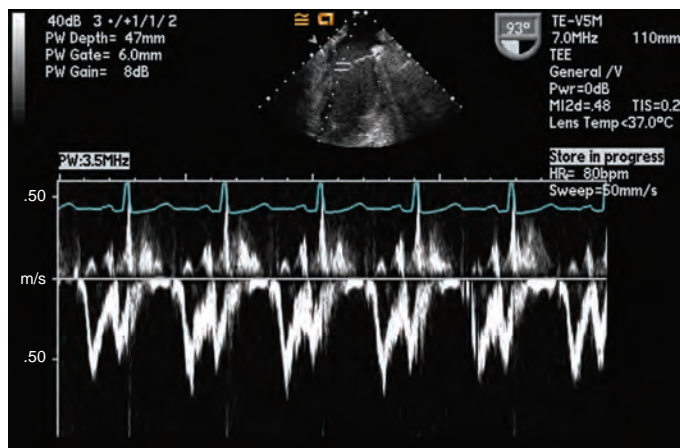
Pulsed-wave Doppler (PWD) versus continuous wave Doppler (CWD). Both images are Doppler spectra through the mitral valve. Left, PWD is used. Because a specific region of interest is defined by the Doppler gate, a clean envelope of transmittal flow is displayed. Right, CWD is used. Because spatial specificity is lost, spectral broadening of velocities are displayed.
